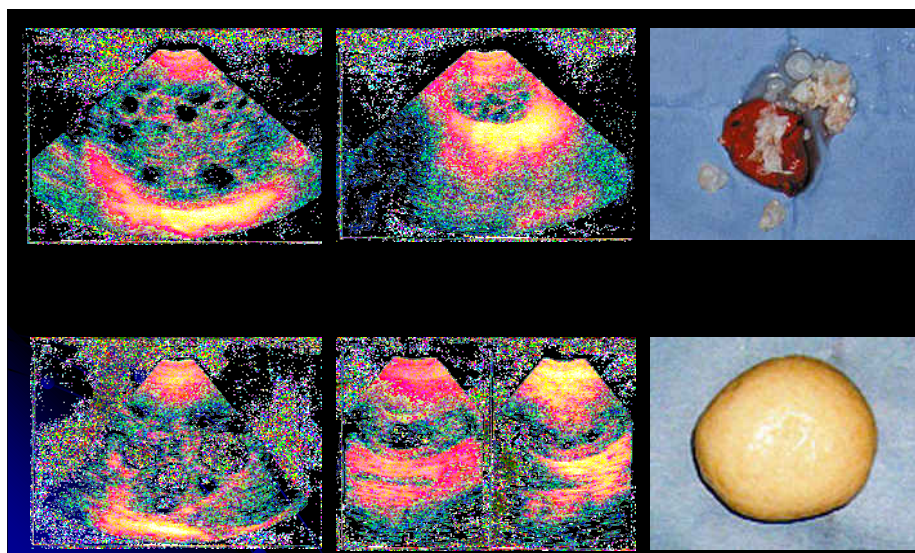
Ultrasound imaging of *Echinococcus* of the liver and Ovarial *Echinococcus*
